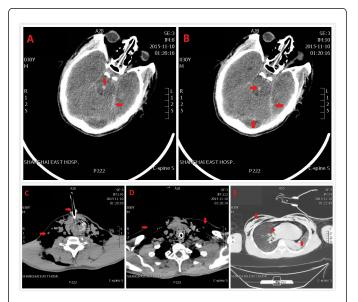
The CT scan shows that the patient has multiple head, neck and thorax traumas. A and B dedicate the multiple intracranial hemorrhage of brainstem, endocranium and arachnoid. C-E shows the pulmonary atelectasis, subcutaneous emphysema and mediastinal displacement.
